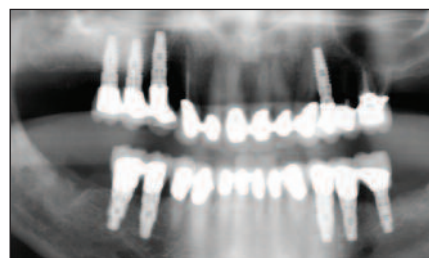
Case 2: Panoramic radiograph showing the final restorations in place.
